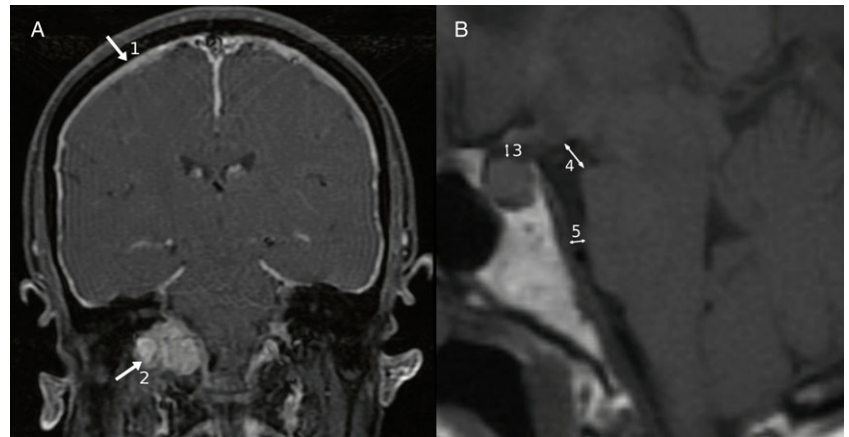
MRI features of intracranial hypotension following radiotherapy of jugular paraganglioma (arrow 2). Pachymeningeal thickening and enhancement (arrow 1) (A), reduced mamillopontine distance (arrow 4: 5.0 mm, pathologic ≤ 6.5), partial effacement of the preoptine and suprasellar cisterns (arrow 5: 3.0 mm, pathologic ≤ 5 mm; arrow 3: 2.4 mm, pathologic ≤ 4.0 mm) (B).⁷
